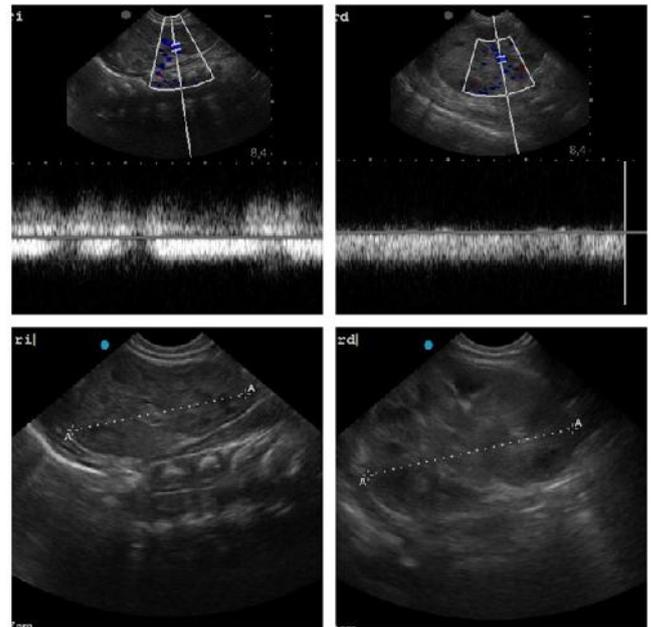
Abdominal ultrasound. Minor asymmetric bilateral intrarenal venous flow is detected in the right kidney. Left kidney 5.37 cm. Right kidney 6.33 cm
